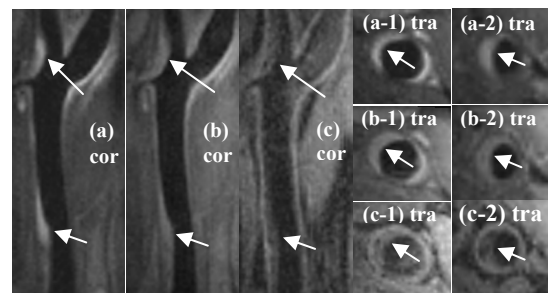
The typical plaque images of T2w- (a) and T1w-SPACE (b), and MPRAGE (c) from a patient with CIS and color Doppler confirmed plaque. The bright signal of the plaque at bifurcation (long arrows) in T2w image suggested the inflammation. The heterogenous signal intensity of the plaque suggested the complex plaque, hence the high-risk plaque.
